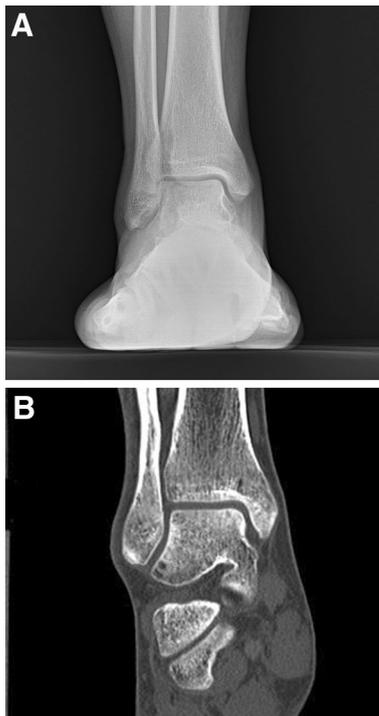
Preoperative anteroposterior standing radiograph and computed tomograph showed a  $7 \times 10$  mm displaced fragment in the centrolateral talar dome
